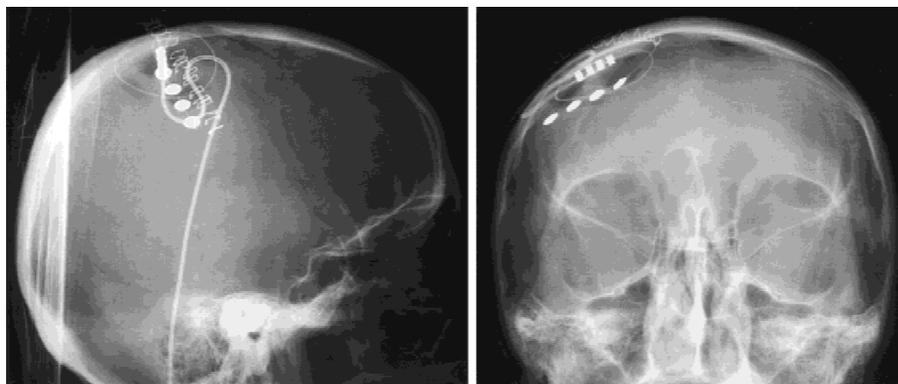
Skull radiographs showing the stimulator in place.
